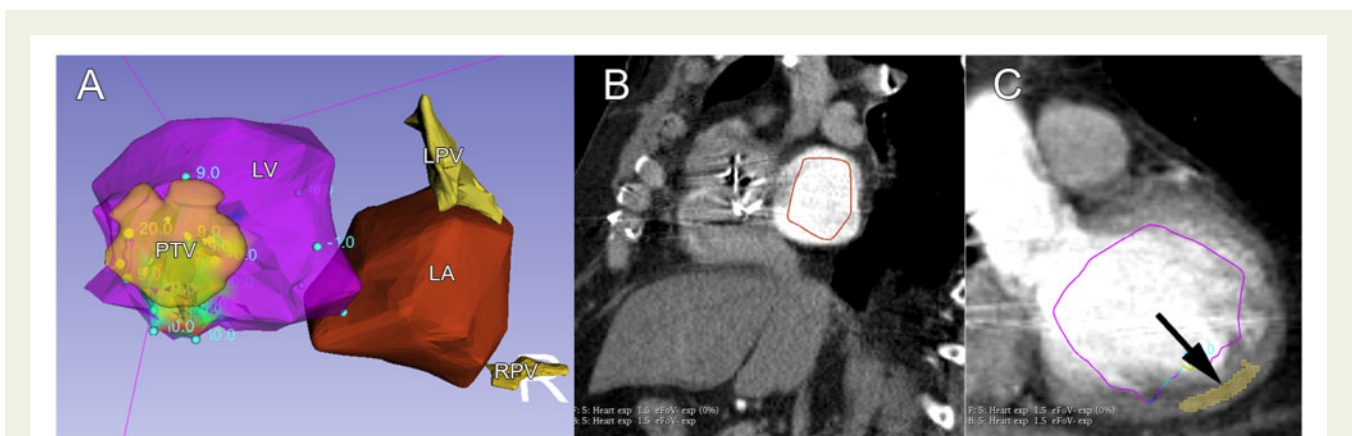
Overview of PTV selection for the second SBRT using the image integration (see text for details). Panel (A) shows a 3D model of the LV and LA imported from the electroanatomical mapping system in dedicated software (slicer.org). Panels (B) and (C) depict endocardial contours of the LA and LV projected onto the raw CT images confirming proper registration. The PTV is projected on the CT slice by yellow colour (arrow). 3D, three dimensional; CT, computed tomography; LA, left atrium; LV, left ventricle; LPV, left-sided pulmonary veins; PTV, planned target volume; RPV, right-sided veins.
